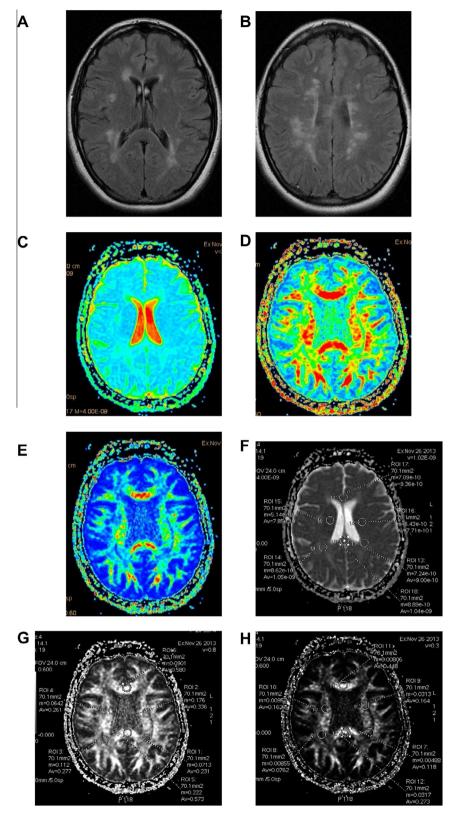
Female patient aged 29 years with RRMS (4 years duration). Multiple hyperintense MS plaques are seen in FLAIR images in centrum semiovale, and anterior limb of internal capsule. MD map reveals multiple areas of increased diffusivity. FA and VR maps showing areas of decreased anisotropy which are much larger than the lesion's appearance on FLAIR images. (A and B) Axial FALIR images. (C–E) DTI directionally encoded color (B: MD, C: FA, D: VR) map. (F–H) DTI directionally encoded (E: MD, F: FA, G: VR) map (ROIs are placed in the genu and splenium of corpus callosum, MS plaques and NAWM).
